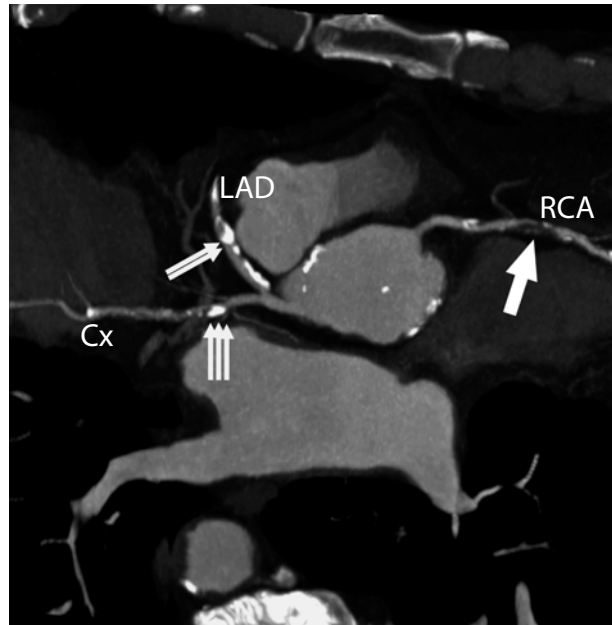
Coronary CT angiography examination of a patient with chest pain. The examination was carried out using a 64-slice CT scanner with 0.6-mm collimation and 0.33-s rotation time. Visualization of all main coronary artery segments in maximum intensity projection (MIP) display reveals multiple lesions. The non-calcified stenosis in the right coronary artery (RCA) can be readily assessed (arrow). While the calcified stenosis in the left anterior descending coronary artery (LAD) can be accurately diagnosed (double arrow), evaluation of the lesion in the narrower circumflex coronary artery (CX) is more difficult due to the blooming of the calcified plaque (triple arrow). (Case courtesy of MUSC, Charleston, USA)
